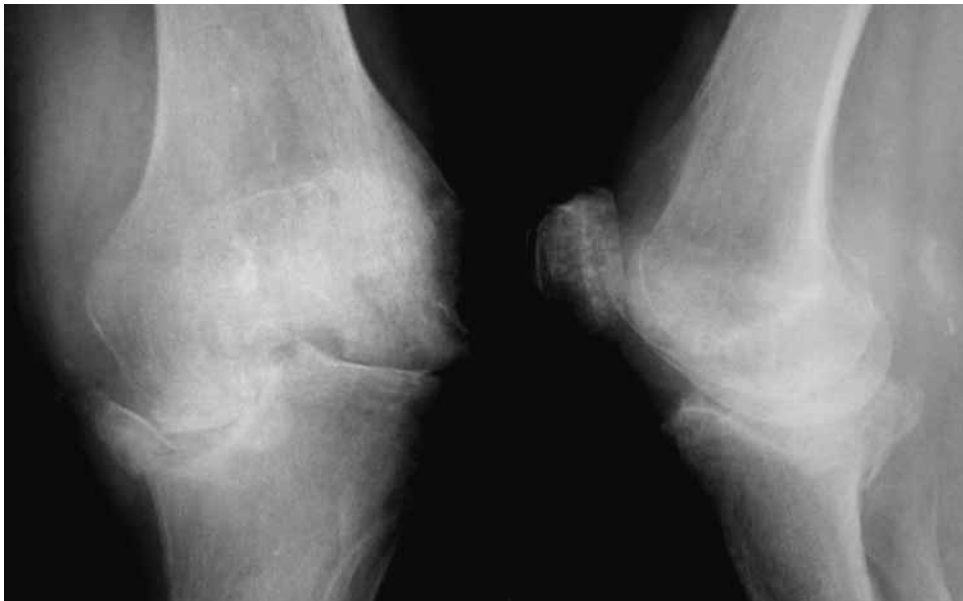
Preoperative radiograph left knee demonstrating 2 week old Schatzker IV fracture
